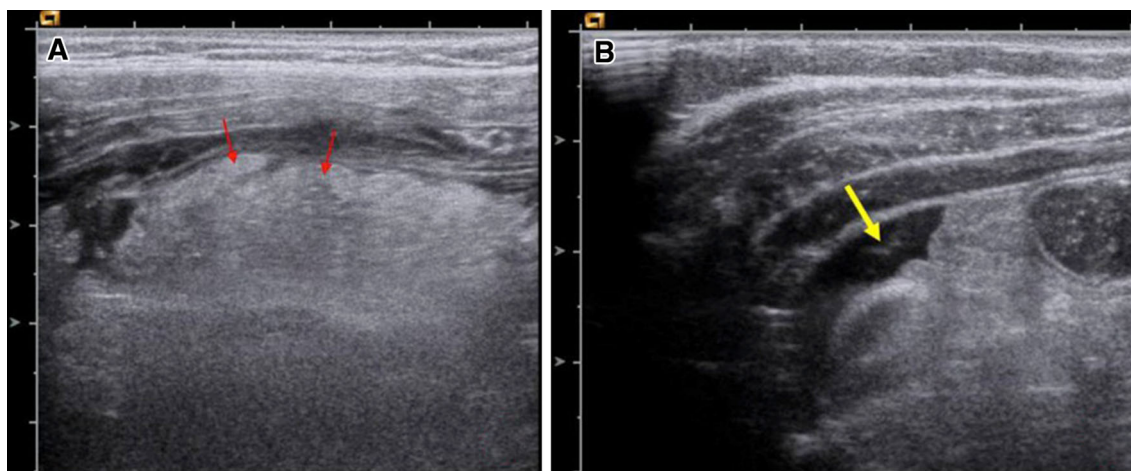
Omental torsion. a, b 10-year-old boy presented with symptoms and signs suggestive of appendicitis. The ultrasound examination of abdomen showed hyperechoic intra-abdominal fat (*red arrows*) associated to the presence of intraperitoneal fluid (*yellow*
